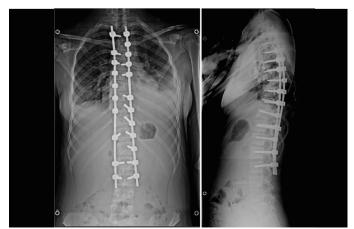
Radiographs following scoliosis correction.
